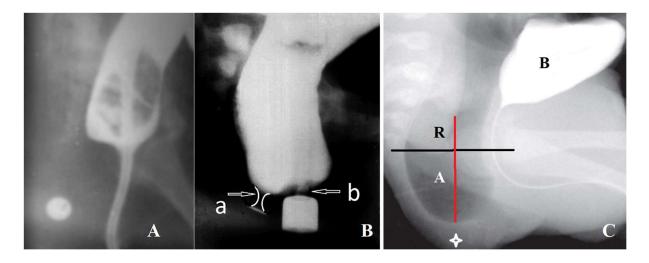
(A-B) The radiographs of the same girl with vestibular fistula performed at different ages. (A). At the age of 3 months the rectum was filled with barium through the catheter, conducted through the fistula. A pushpin is located near anal dimple. The distal intestine, with a length equal to the length of the normal anal canal, constantly contracted around the catheter, preventing leakage of barium. (B) At the age of 9 months, during a barium enema the wide opening of the anal canal occurred. The distance from the pushpin to the distal wall of the open anal canal equals 4 mm (a). Barium does not penetrate outward, since the tip of the enema occluded the narrow and rigid ectopic anus (b). The true diameter of the marker on the enema tip is 1.6 cm. The width of the rectum is 4.3 cm at the maximum rate for children under 1 year is 3 cm. Conclusion: anovestibular ectopy, megarectum. The diastasis between the anal canal is (4 mm) the thickness of the skin and subcutaneous tissue. (C) Radiograph of a newborn boy with perineal fistula during a reflex opening of the anal canal. The distance from the blind end of the anal canal to the anal dimple is 2 mm. P-C line (black). Axis of anal canal (A) and rectum (R) (red line).
